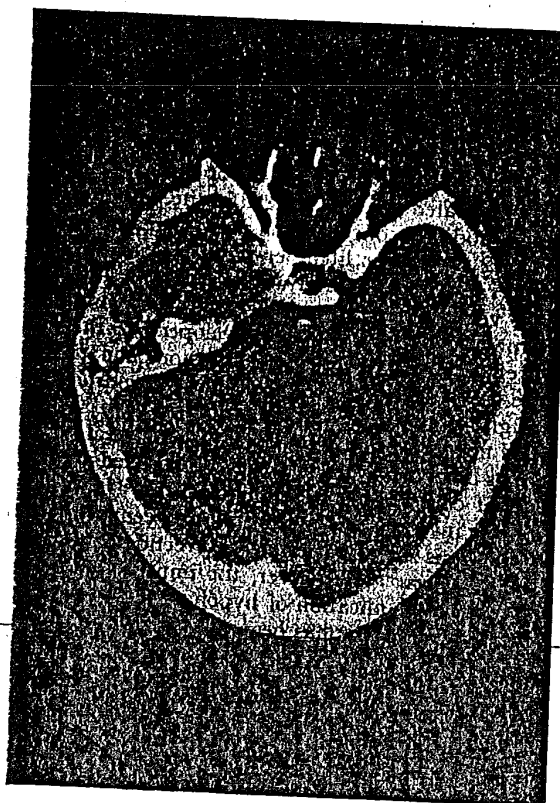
CT-Scan Section of Patient 2, Demonstrating Large Area of Decreased Attenuation in the Center of the Brain Stem at the Level of the Pons.
